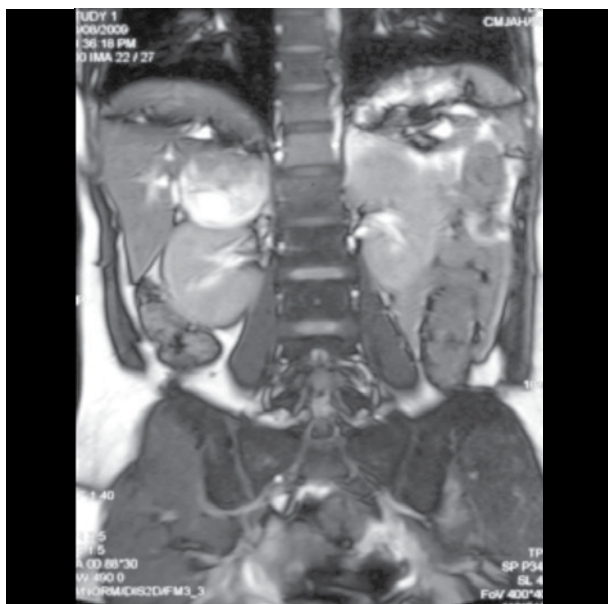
MRI abdomen index patient, Case 2
